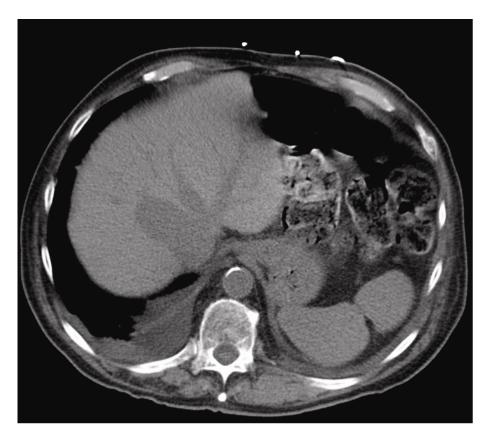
CT scan demonstrating large intrahepatic portal-hepatic venous shunt
